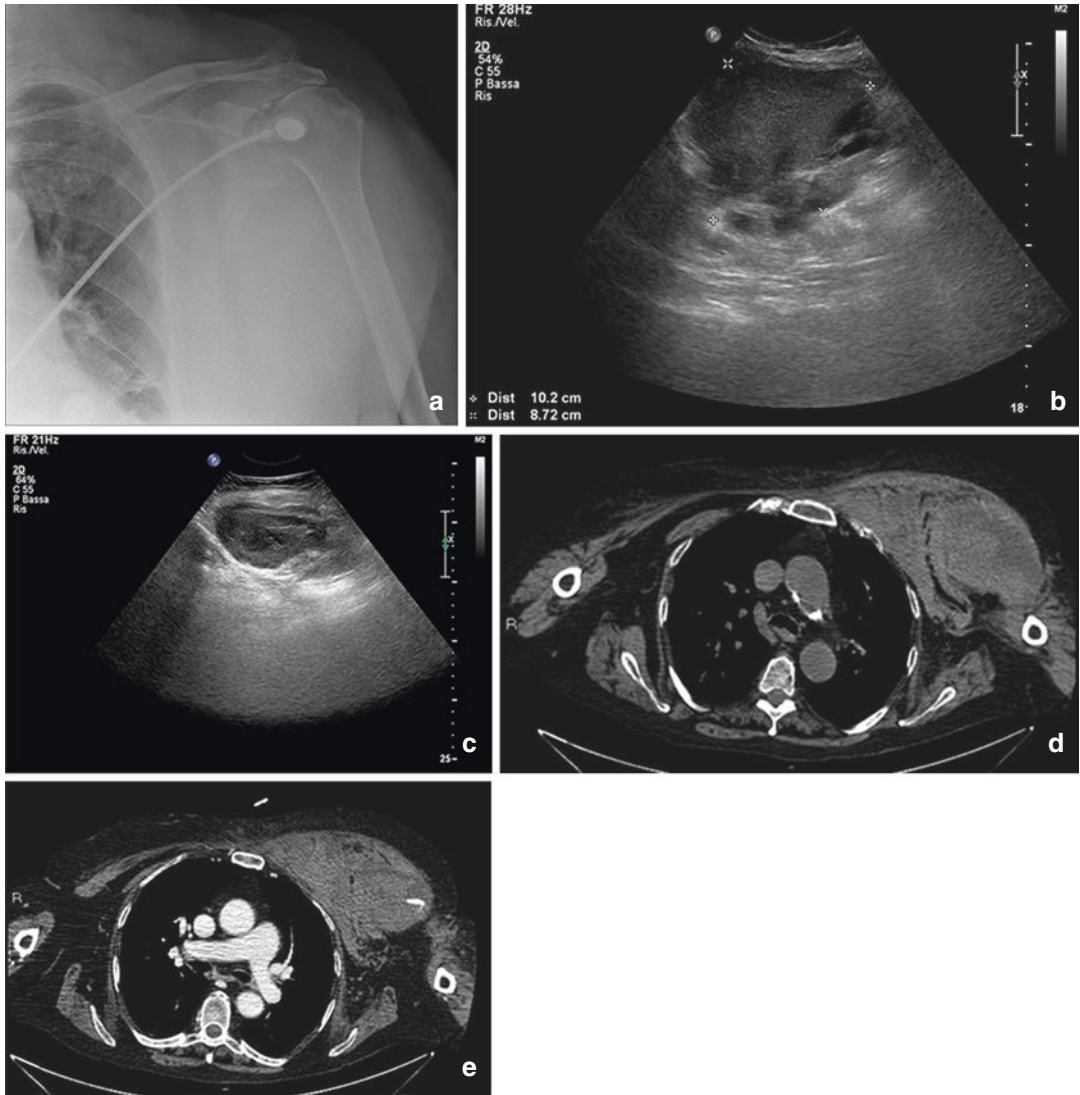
Pectoral hematoma. The X-ray showed a soft tissue thickening (a). TUS (b, c) showed a complex echotexture formation that, together with the case history, allowed the diagnosis of a hematoma. The CT (d, e), on
